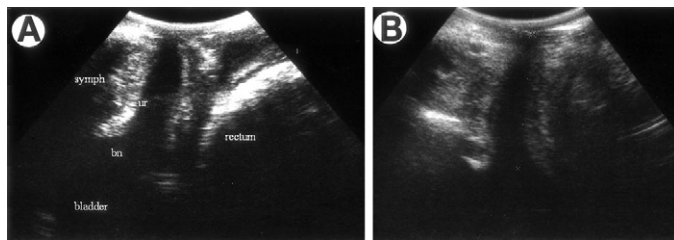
Perineal ultrasound. A, sagittal view of same constipated patient demonstrates lower limit of distended rectum. Ultrasound transducer was placed on urethral meatus. *symph*, symphysis. *ur*, urethra. *bn*, bladder neck. B, normal female urethra with empty rectum behind it.
